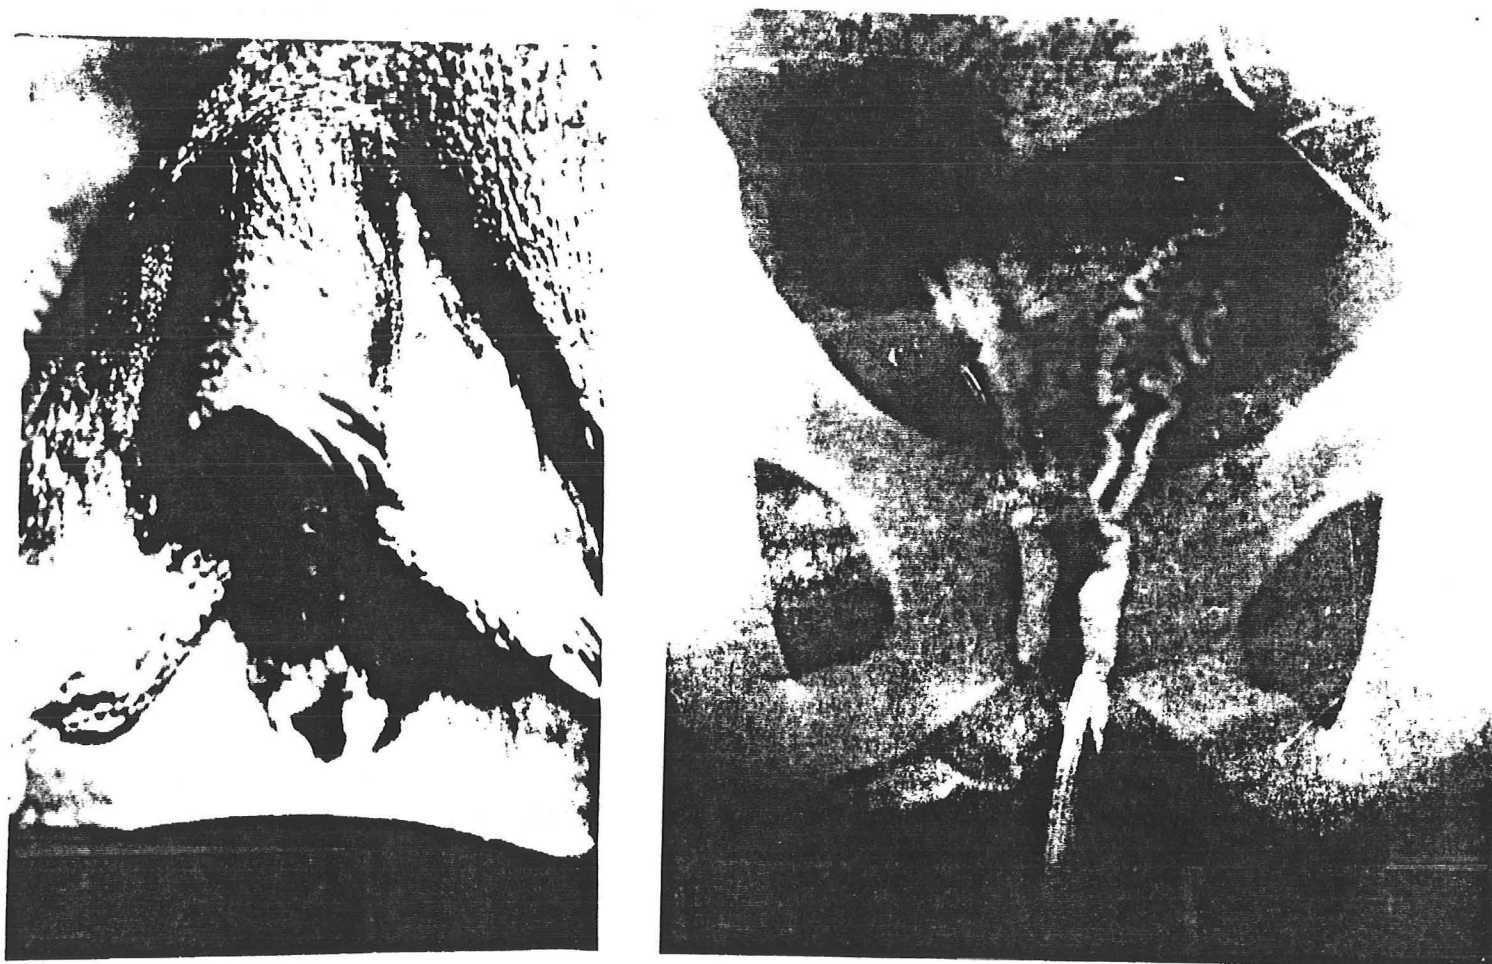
External genitalia and internal ducts of a patient with steroid 5 $\alpha$ -reductase 2 deficiency (Ref. 5). Left: photograph of external genitalia showing clitoromegaly and the opening of a pseudovagina. Right: X-ray of the abdomen after injection of diatrizoate sodium into the vasa differentia at the time of abdominal surgery. vd, vas deferens; sv, seminal vesicles; ed, ejaculatory ducts. The dye emptied into the vagina.
